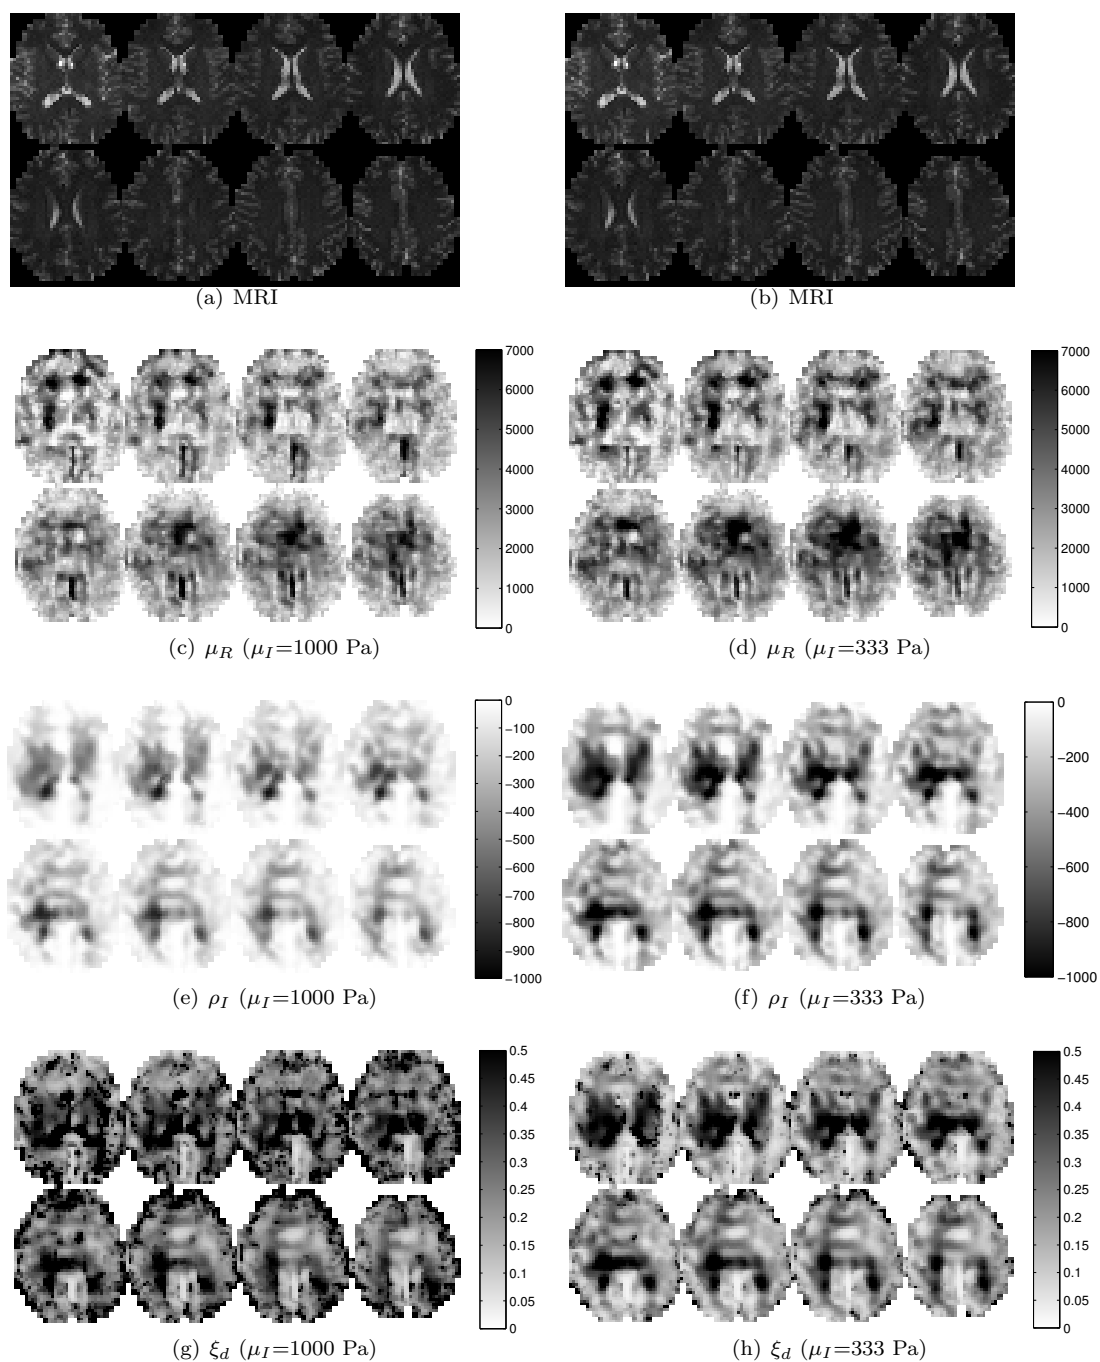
Image results for parametric-based RD reconstruction of the same *in vivo* healthy brain at 50 Hz with globally defined $\mu_I=1000$ Pa (left column) and $\mu_I=333$ Pa (right column): (a) and (b) T1-weighted MP-RAGE MRI image of the brain; (c) and (d) storage modulus μ_R image (Pa); (e) and (f) imaginary density ρ_I image (kg/m^3); and (g) and (h) damping ratio ξ_d image (%).
